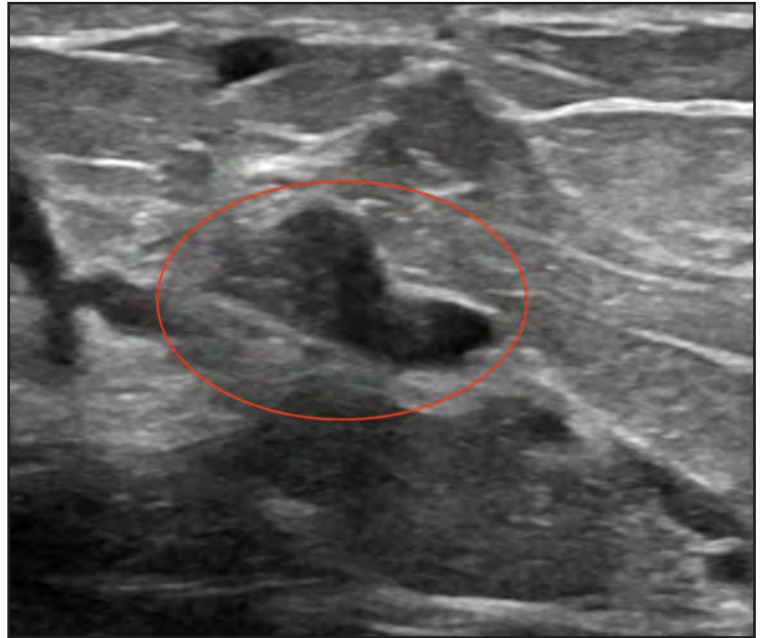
Targeted B-mode ultrasound of the 12 o'clock subareolar region of the left breast in the sagittal plane demonstrates an intraductal mass (oval) corresponding to the ductogram location. Distinct filling defect correlating with this intraductal mass was not seen on ductogram. Biopsy under ultrasound guidance ultimately demonstrated a papilloma with atypia.
